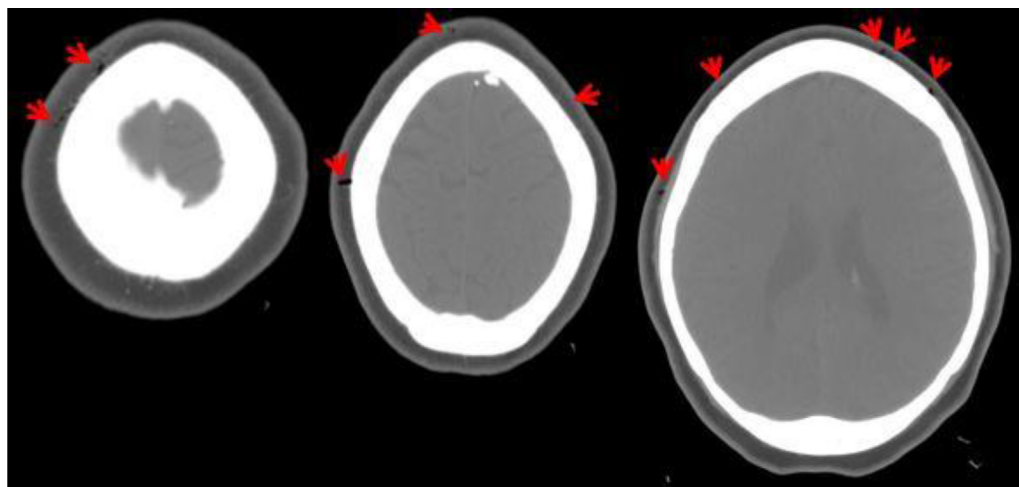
High-resolution axial CT of the head using a lung window demonstrating subcutaneous emphysema of the scalp (arrows). CT, computed tomography.
